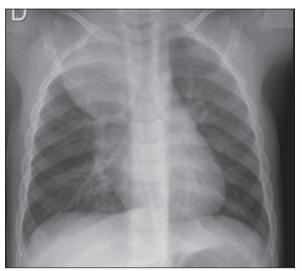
Chest x-ray. A lesion of 6 cm in diameter is observed in the vertex of the right lung.
